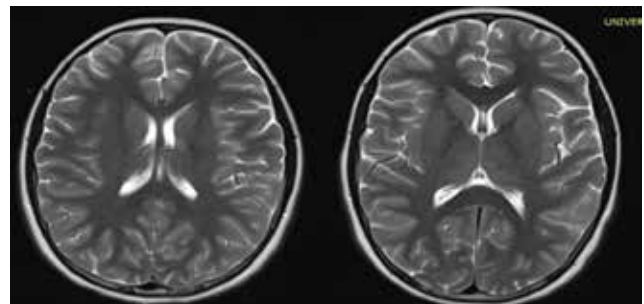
MRI findings of the endocranium of patient 1: signal changes of the parietal and occipital cortex of both hemisphere
